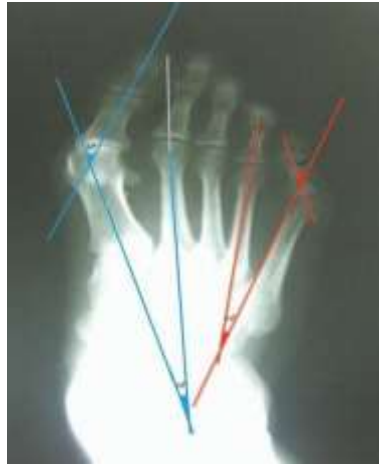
Preoperative weightbearing AP radiograph demonstrating forefoot deformities calculations.
